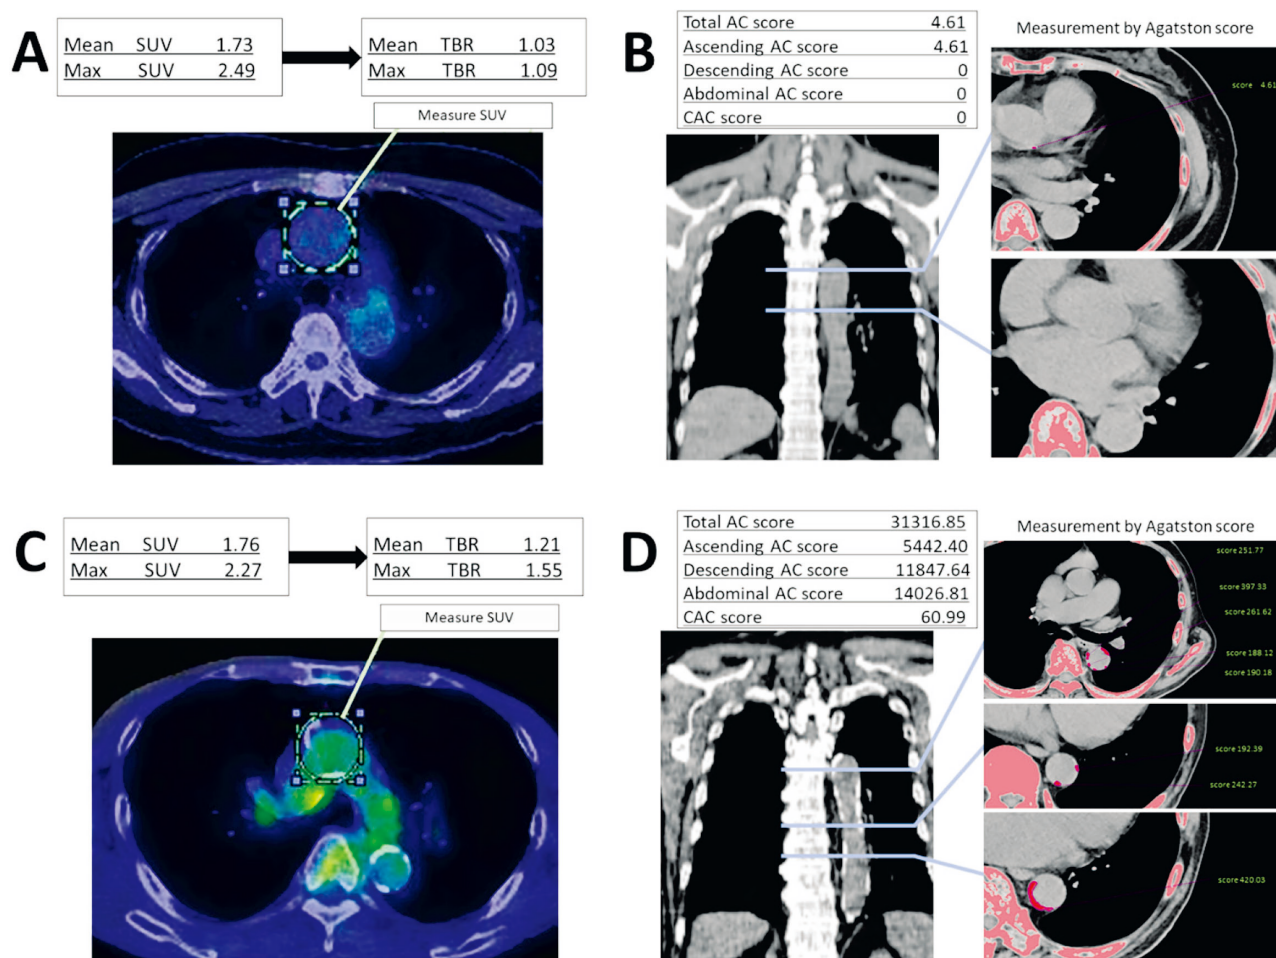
Image of visualization of ^{18}F -FDG uptake analysis in PET/CT and aortic calcification score with Agatston score in non-contrast CT.
